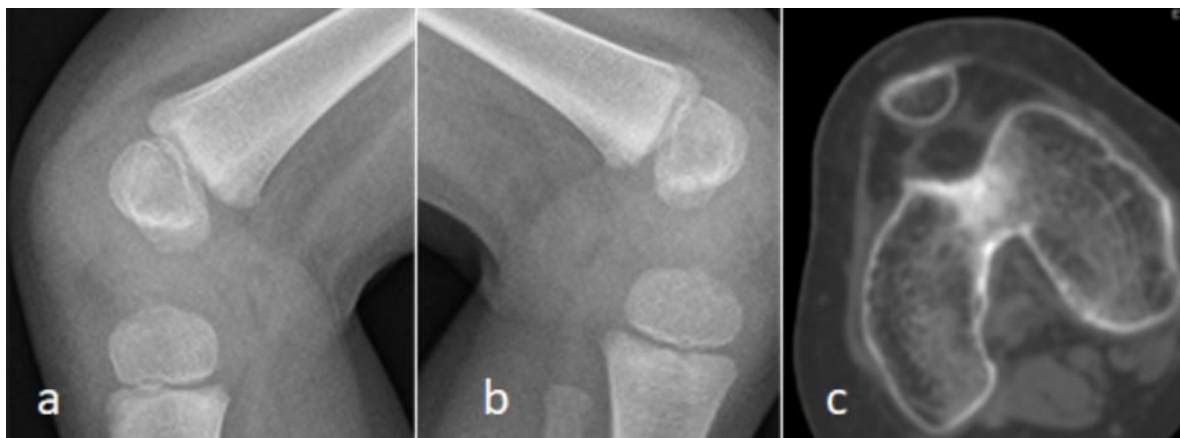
Lateral knees radiograph in an 8-years-old boy showed bilateral and symmetrical absent patellae (a,b). 3D axial CT scan of another patient with Nail-Patella syndrome of a 13-years-old-boy showed a rudimentary dysplastic patella but almost a rounded dysplastic type and irregular and dysplastic trochlea, note the maltracking of the instable and dysplastic patella (c).
